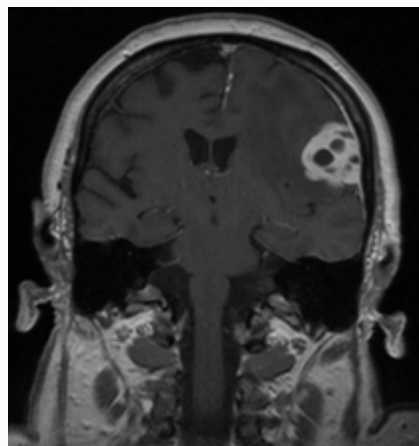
Case 3: MRI Siemens MAGNETOM SKYRA 3-T examination revealed an extra-axial mass adherent to left frontal convexity dura mater in correspondence Broca's area, suggestive for hemorrhagic meningioma.
